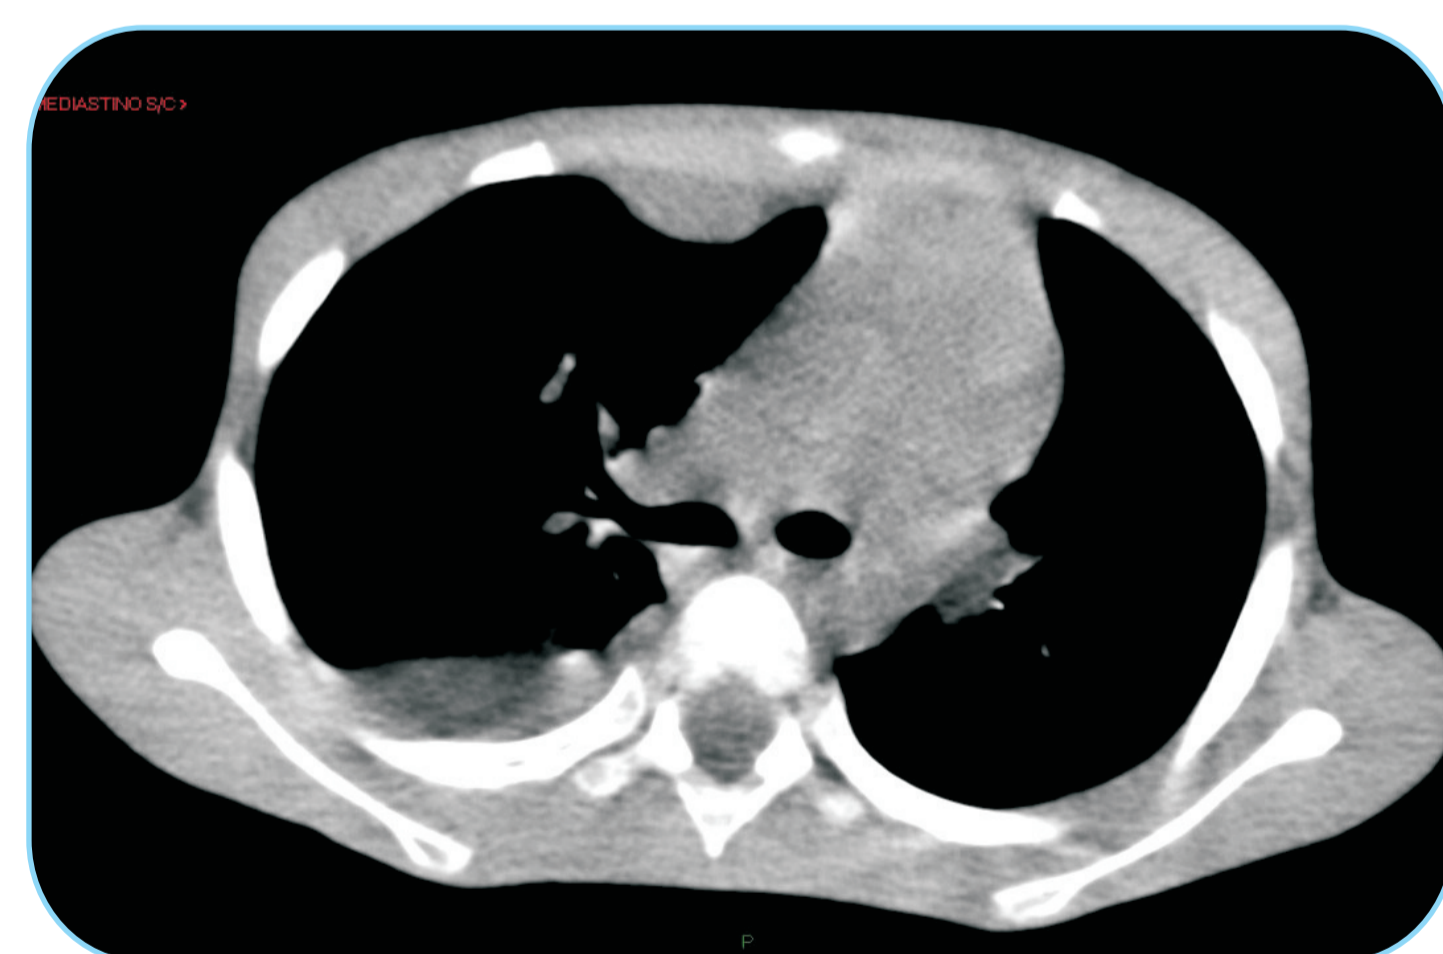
CT thorax. March, 2015.
